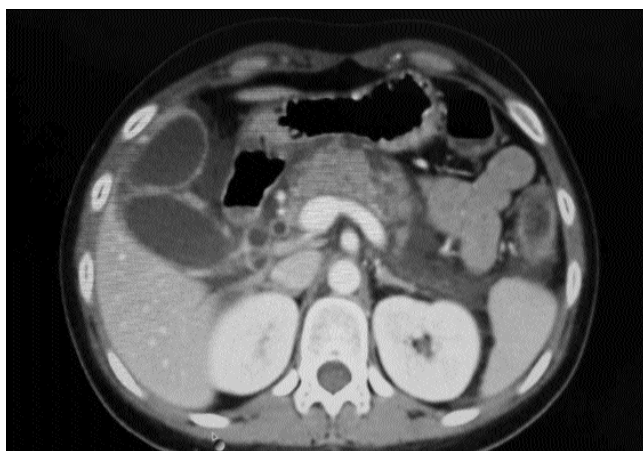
Computed tomography (CT) scan axial images of a 22-year-old male patient showing pancreatic necrosis (white arrow) and peripancreatic fluid collection (black arrow).
